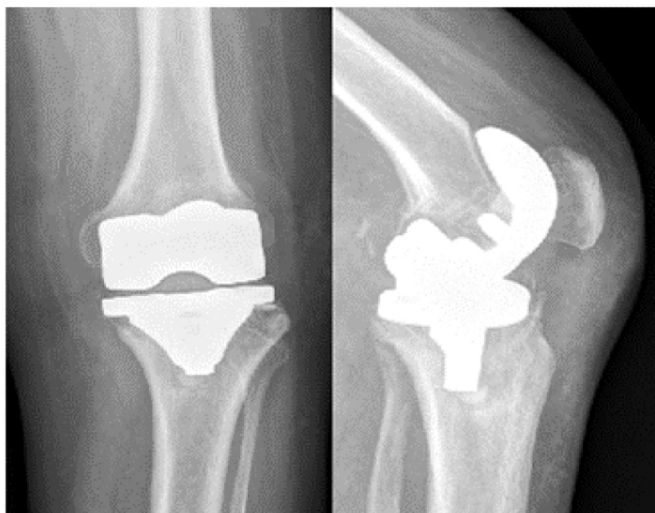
Preoperative radiographs showing tibia and femoral loosening.
